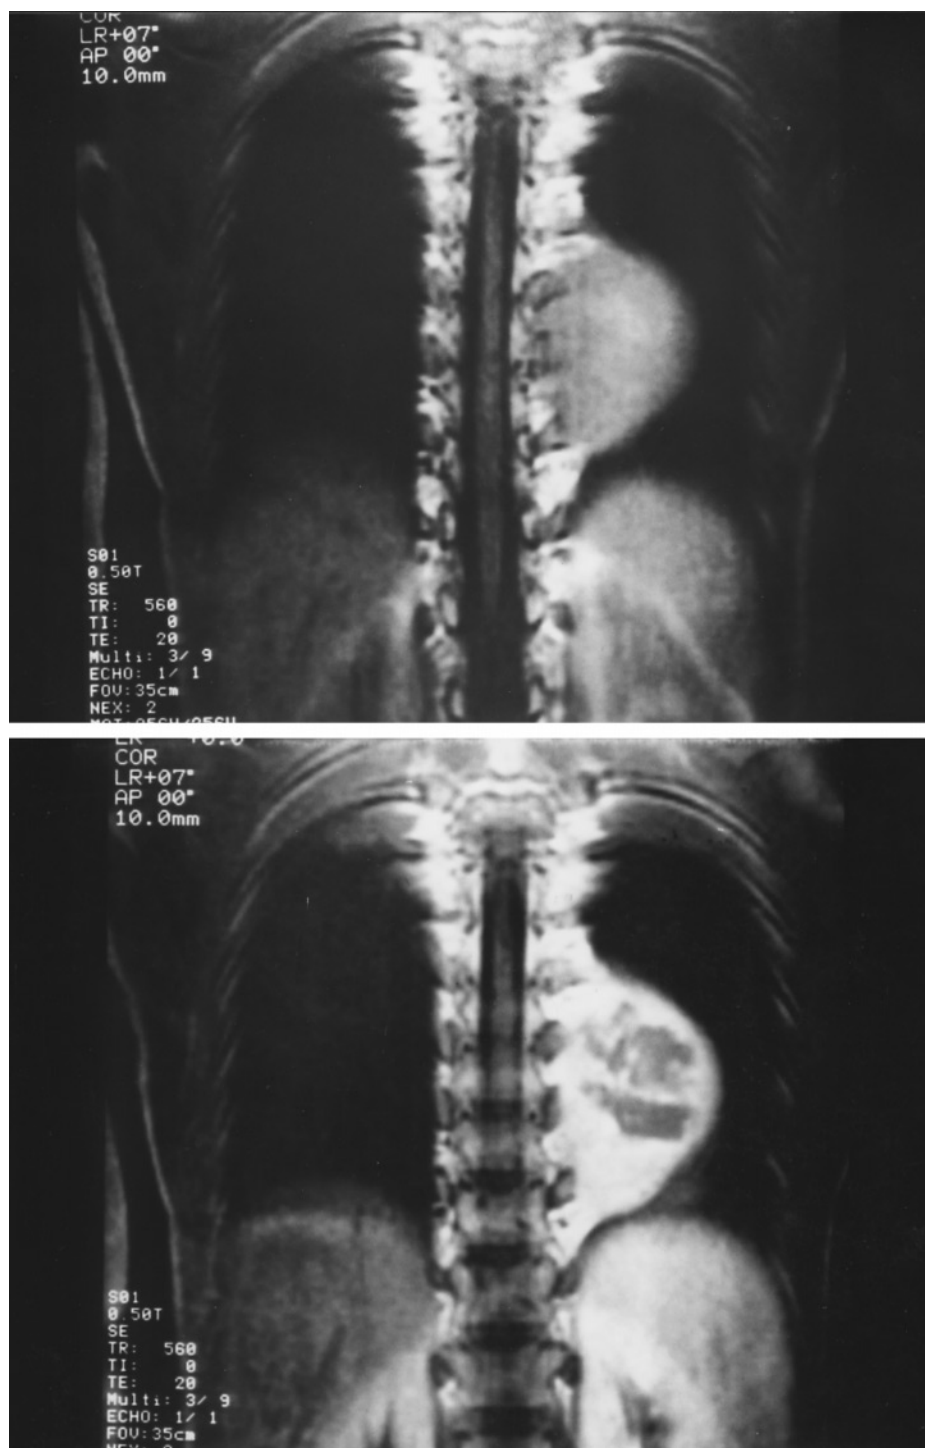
Magnetic resonance imaging cuts. (Top) T1- weighted image (TR 560/TE 20): the mass appears isodense. (Bottom) T1-weighted image after gadolinium injection showing a strong and heterogeneous enhancement of the mass. No intraspinal extension.
